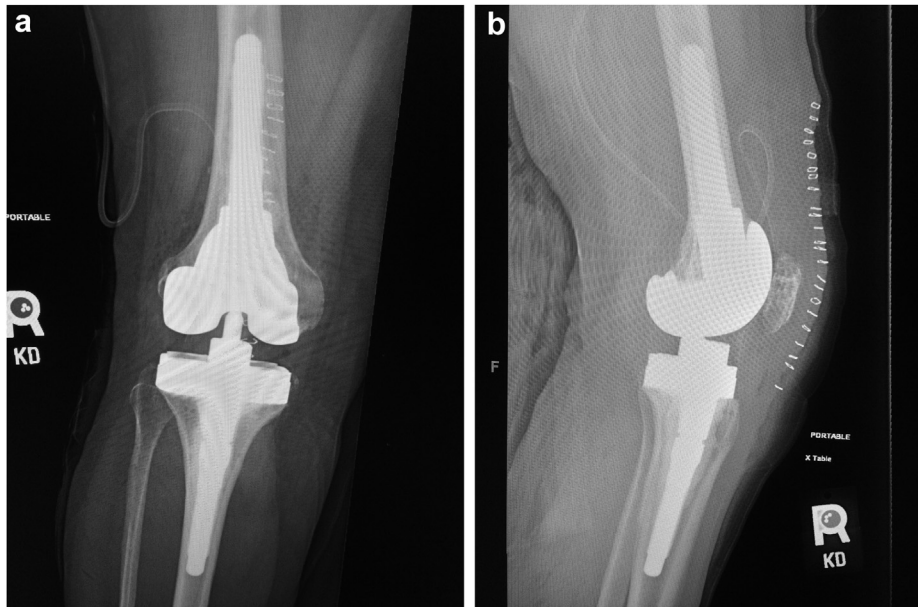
AP (a) and lateral (b) radiographs of the left knee after conversion to a hinge knee arthroplasty with medial retinaculum repair.
